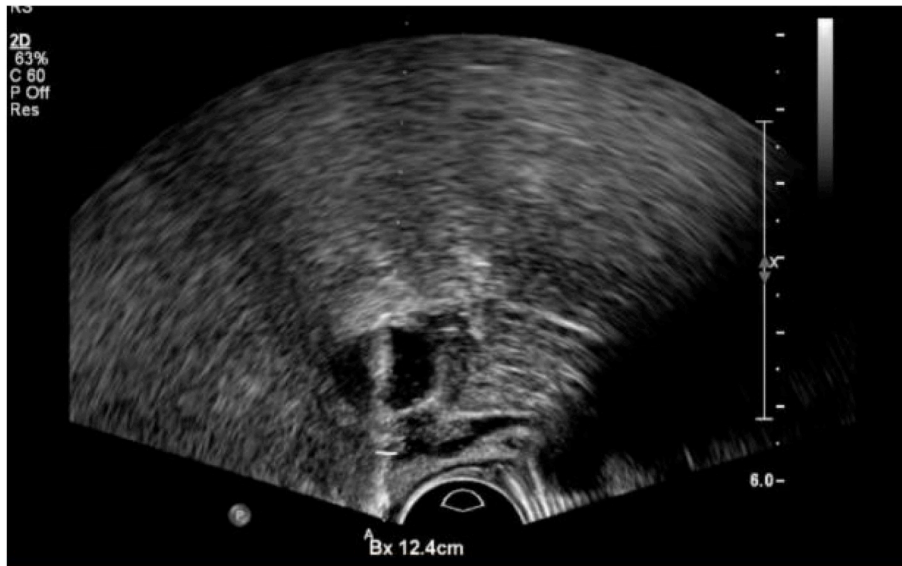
Biopsy of right-sided pelvic lymph node. UroNav (Philips/Invivo, Gainesville, FL) imaging obtained during MRI targeted biopsy showing successful needle biopsy.
